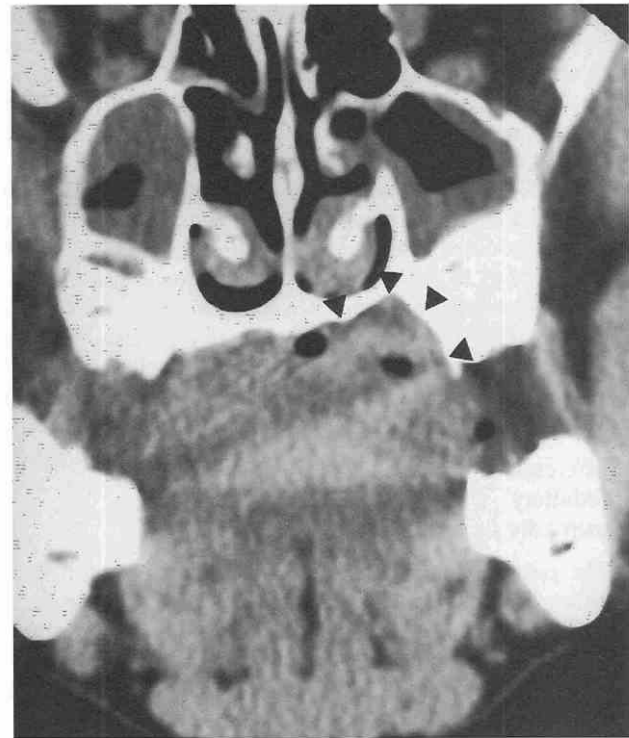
Nasopharyngeal carcinoma. Coronal noncontrast CT scan. A soft tissue mass is present in the roof of the oral cavity, causing erosion of the hard palate and maxilla (arrowheads).
